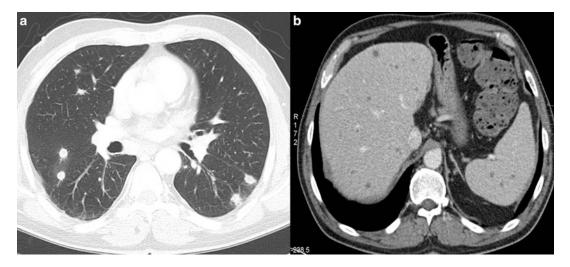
Systemic candidiasis in a 40-year-old male patient with chronic myeloic leukemia. (a) Axial CT scan shows multiple bilateral intrapulmonary nodules
